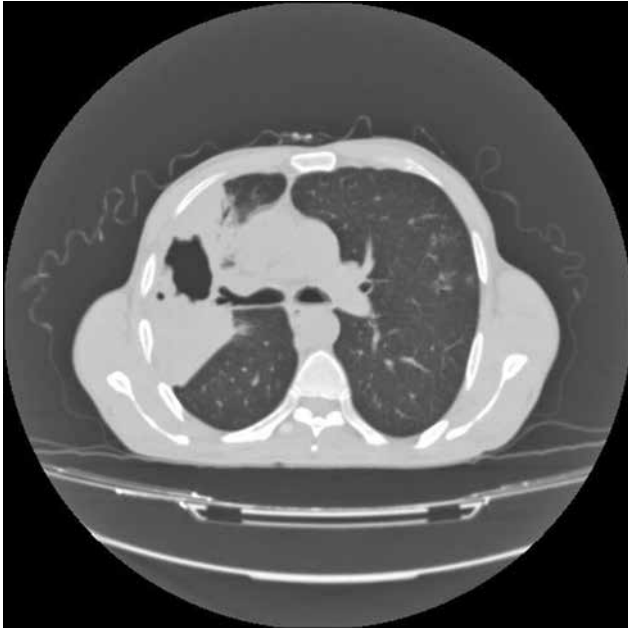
An axial computed tomography image showing a ruptured right lung hydatid cyst.
